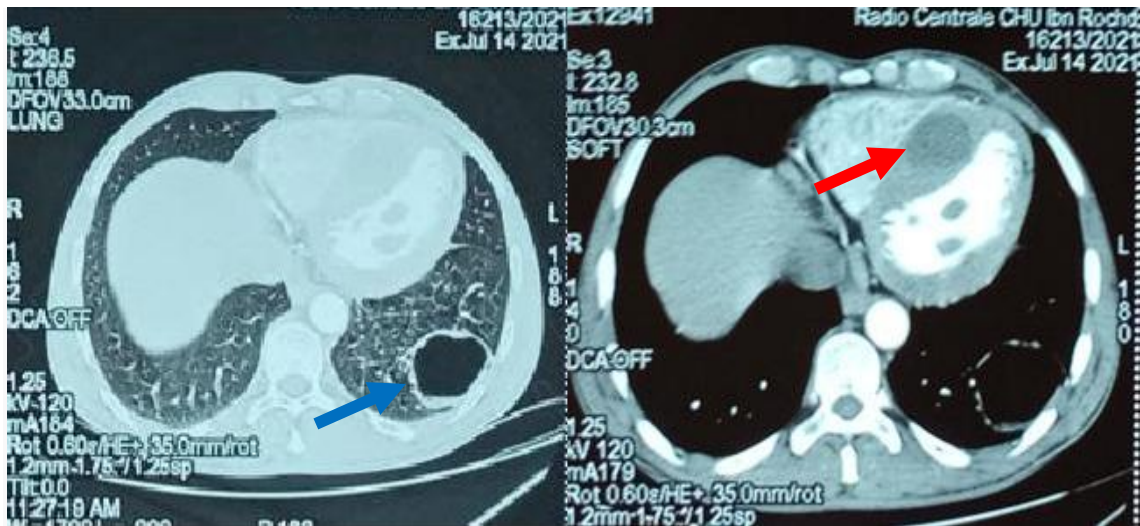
TAP CT scan at the thoracic level: Cross section passing through C5:
